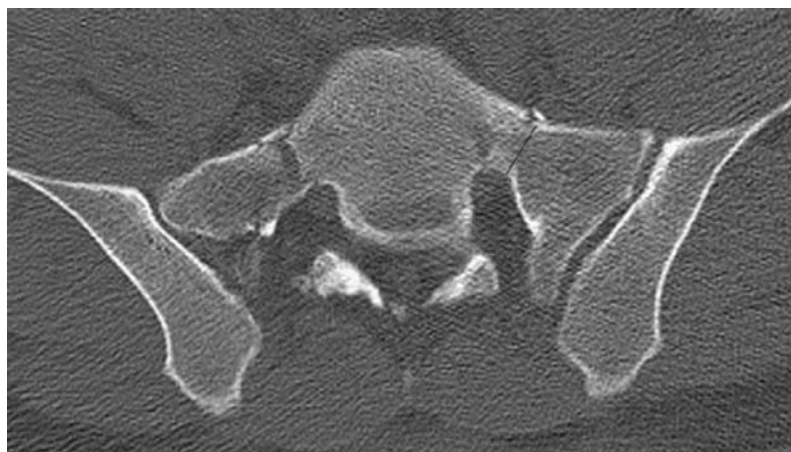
This pelvic CT axial image allows the surgeon to quantify the narrowest alar zone for S1 iliosacral screw insertion as well as the oblique pathway and length for the upper sacral dysmorphic segment.
